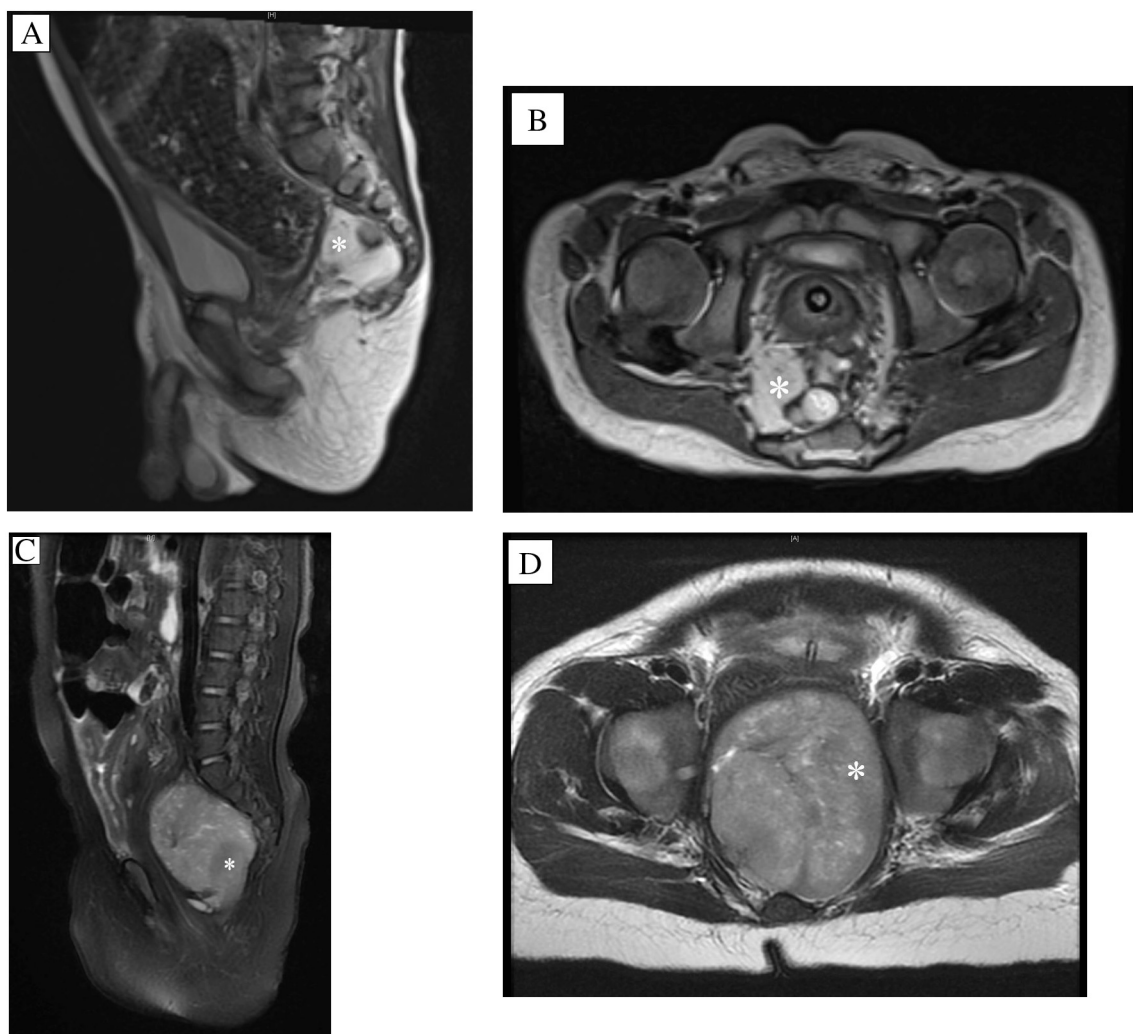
T2 weighted pelvic magnetic resonance imaging demonstrating a presacral mass in a patient with (A and B) and without (C and D) an ARM. A) Sagittal and B) axial images of a patient with an ARM and presacral mass with fatty and cystic components projecting into the pelvis from the sacral canal. C) Sagittal and D) axial images of a patient without an ARM and a large solid presacral mass (mass denoted by * in all images).
